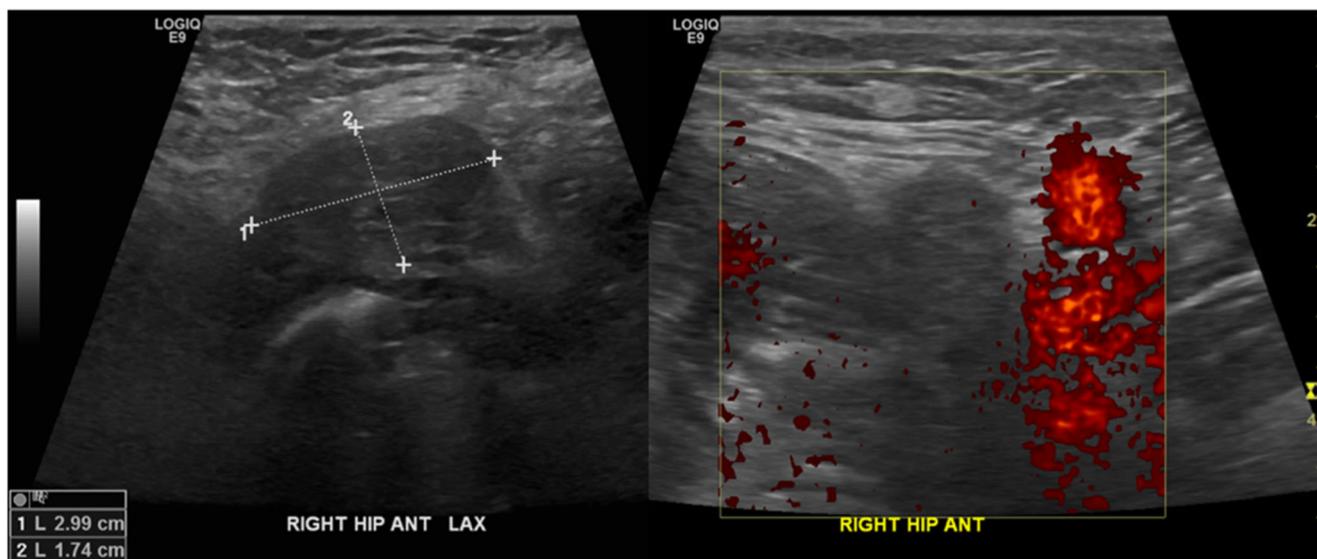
A 65-year-old asymptomatic female with a metal-on-metal right total hip arthroplasty. Long-axis (left) grayscale sonographic image and power Doppler sonographic image (right) of the anterior right hip shows a
